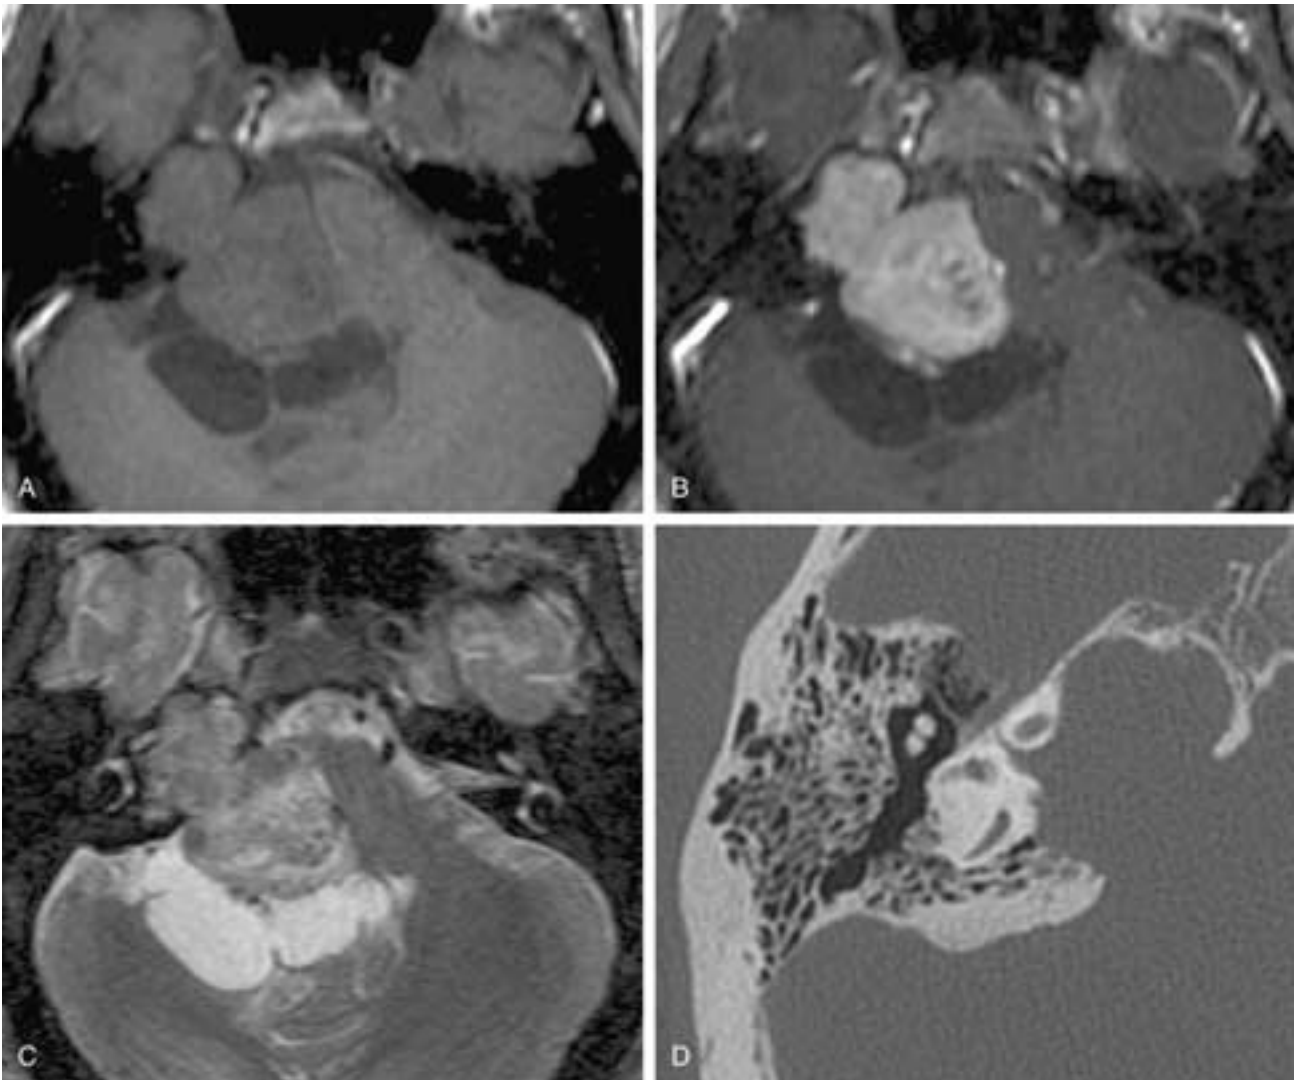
Giant cystic vestibular schwannoma with accompanying arachnoid cysts. A and B, T1-weighted images before and after gadolinium enhancement. Note the superficial arachnoid cysts. The tumor is invading to the petrous apex and compressing the brainstem and the fourth ventricle, causing hydrocephalus. C, T2-weighted image. The tumor is heterogeneously hyperintense and is surrounded by vascular structures and hyperintense cysts. D, CT bone windows. Note the smooth osseous expansion of the petrous apex and IAC.
